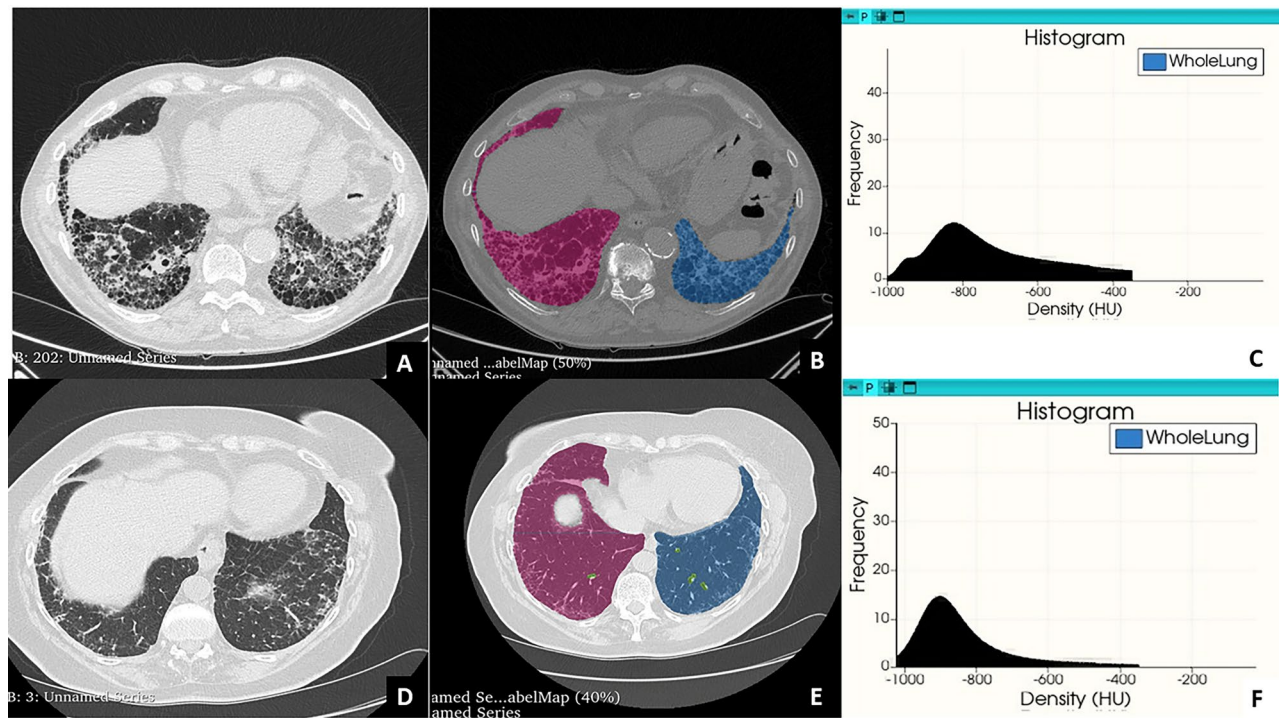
High resolution chest CT findings in a patient with a usual interstitial pneumonia (UIP) pattern (A) and automated color-coded lung segmentation in a single representative slice (B). Representative histogram of the whole density of the lungs (C). High resolution chest CT findings in a patient with a probable usual UIP pattern (D) and automated color-coded segmentation in a single representative slice (E). Representative histogram of the whole density of the lungs (F).
